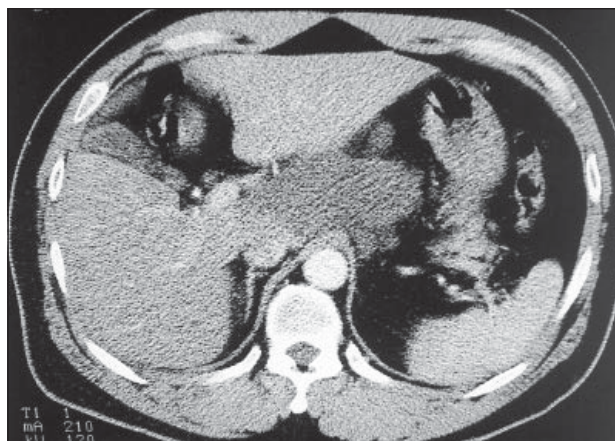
Post-contrast computed tomography image shows no enhancement of the lesion, which is located in the retroperitoneal space.
